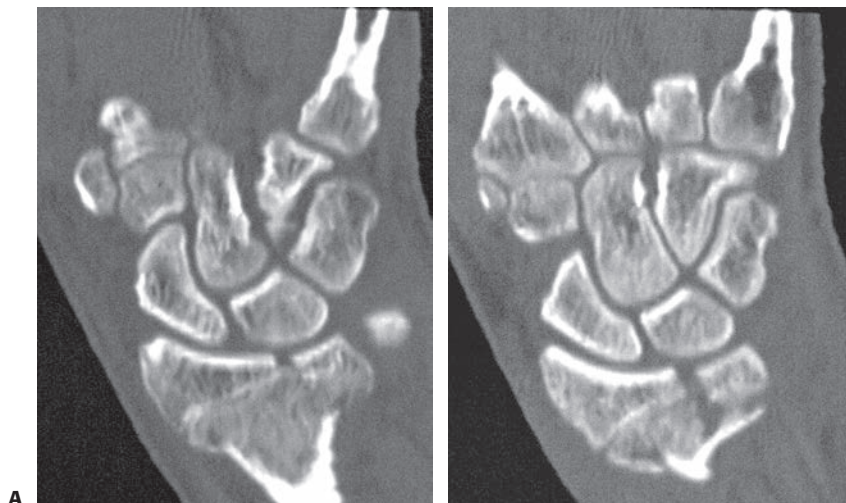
A: CT scan of a displaced intra-articular fracture of a nearly skeletally mature adolescent.
